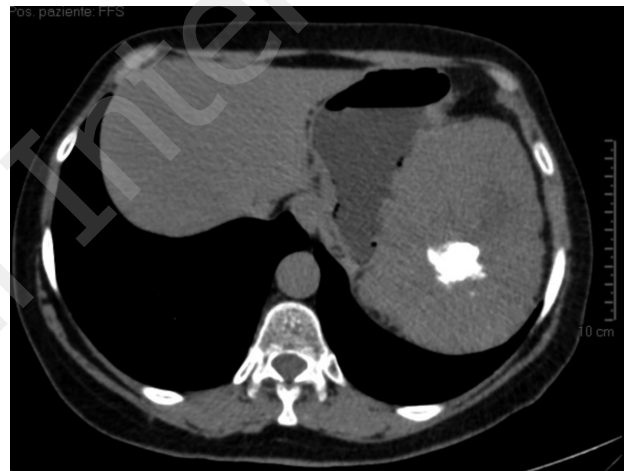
Unenhanced CT image: inhomogeneous tumor mass invading the left upper abdomen with irregular calcified inclusions, approximately in the center of the mass. Isodense appearance compared with the normal liver parenchyma.
